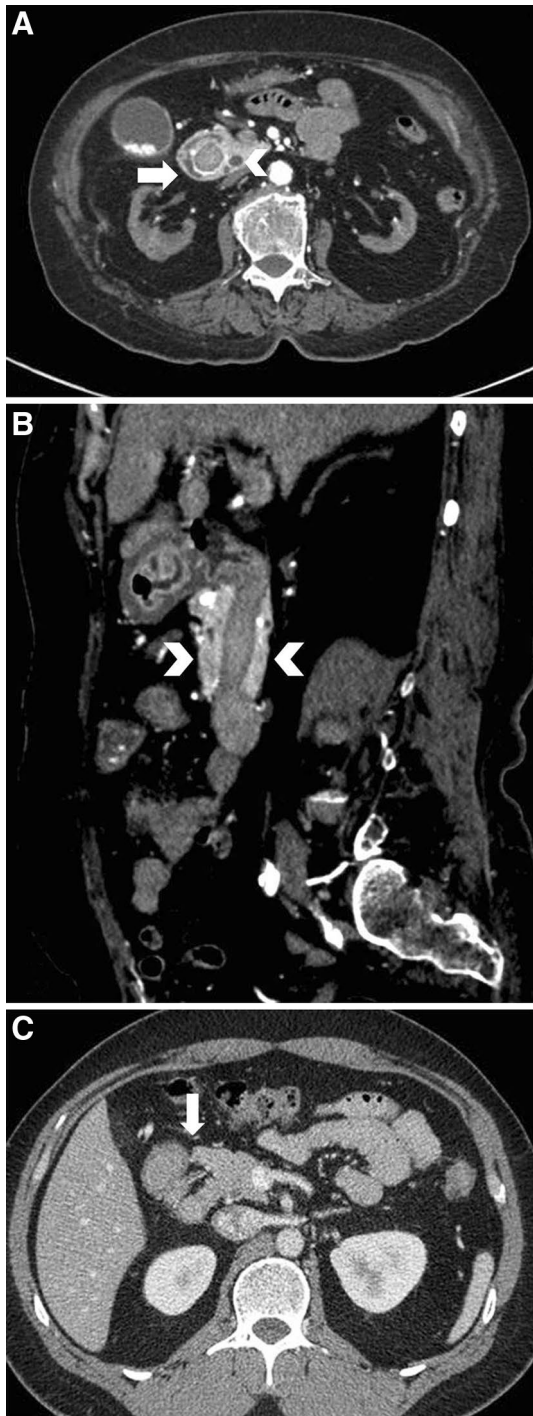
Annular pancreas and incomplete annular pancreas. a, b A 35-year-old man with nausea and vomiting. Axial CT image, a, shows circular rim of pancreatic tissue with annular duct (*arrow*). *Arrowhead* indicates CBD. Sagittal CT image, b, shows pancreatic tissue around the second part of the duodenum (*arrowheads*). Findings are consistent with complete annular pancreas. c Axial CT image in 24-year-old man with abdominal discomfort shows pancreatic tissue semi-circumferentially extending around the second part of the duodenum, giving a crocodile jaw appearance (*arrow*), consistent with incomplete annular pancreas
